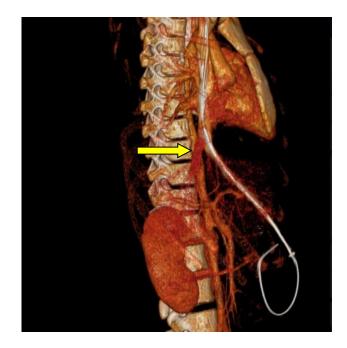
Guide wire inside sheath showing the course on 3D CT reconstruction.
